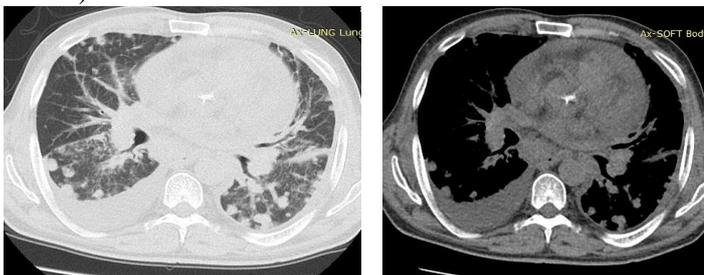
CT shows lung metastasis a) pulmonary window. b) mediastinal window.
